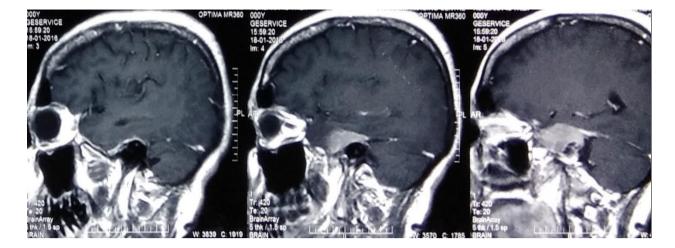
MRI Brain (axial, coronal and saggital images) of patient done preoperatively 1 yr back, showing homogenously contrast enhancing lesion in right cavernous sinus.
